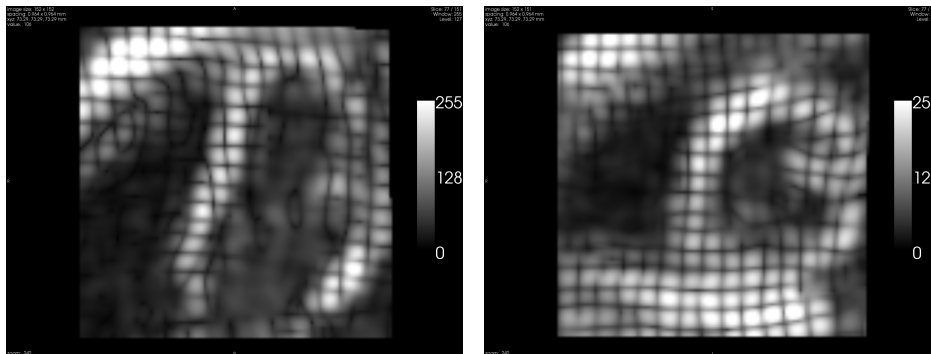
Example of tagged MR images. Left: long axis view with resolution 0.9 mm x 0.9 mm; Right: Short axis view with resolution 0.9 mm x 0.9 mm.
